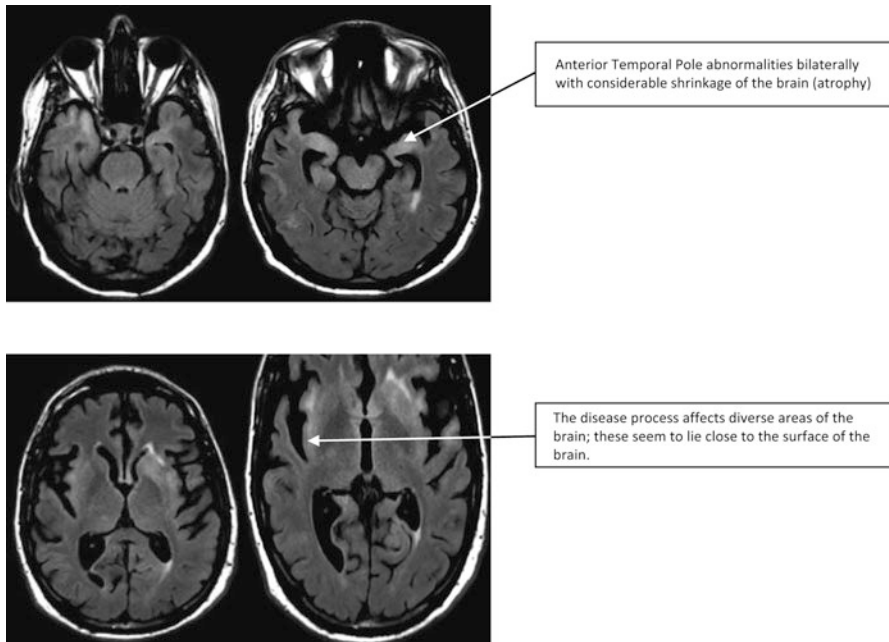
MRI images of a 35-year-old male with rapidly progressive dementia. The pattern of signal changes involves certain key areas of the brain including anterior temporal poles, external capsule, and subinsular regions which can be seen with CADASIL [5]
